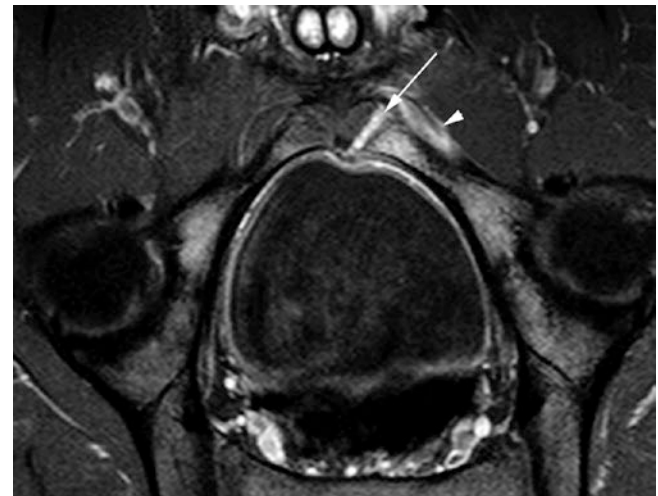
Apophyseal injury. A 16-year-old soccer player with severe left-sided pain. Axial oblique T2FS MR image shows severe left pubic body and ramus bone marrow edema with adjacent soft tissue edema (arrowhead). The apophyseal junction is ill-defined, widened, and of high signal (arrow). (Reproduced with permission from reference Madani H, Robinson P. Top-Ten Tips for Imaging Groin Injury in Athletes. *Semin Musculoskelet Radiol.* 2019;23(4):361–75.)
